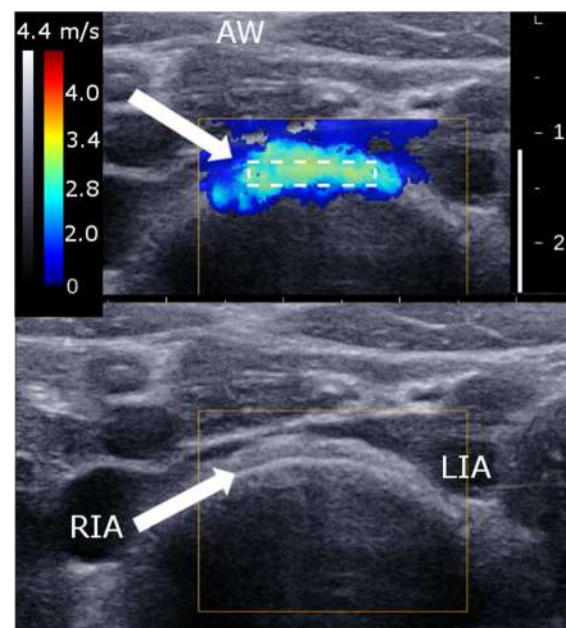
Example of elastographic image (top frame) and ultrasonography (bottom frame) of lumbar intervertebral disc in an 8 years old girl. The *annulus fibrosus* is indicated by the white arrow (*lamellae* are visible). Abdominal wall (AW) is visible in the top of the image. Right and left common iliac arteries (RIA and LIA) are also visible. The dashed rectangle is the region of interest (ROI) in the *annulus fibrosus*.
